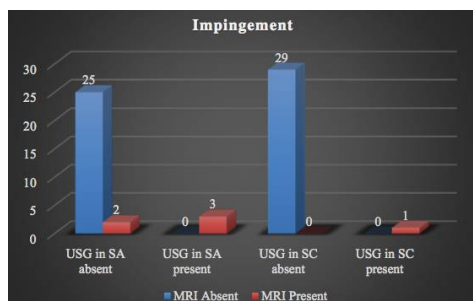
Association between USG findings and MRI findings in detecting Impingement lesions
